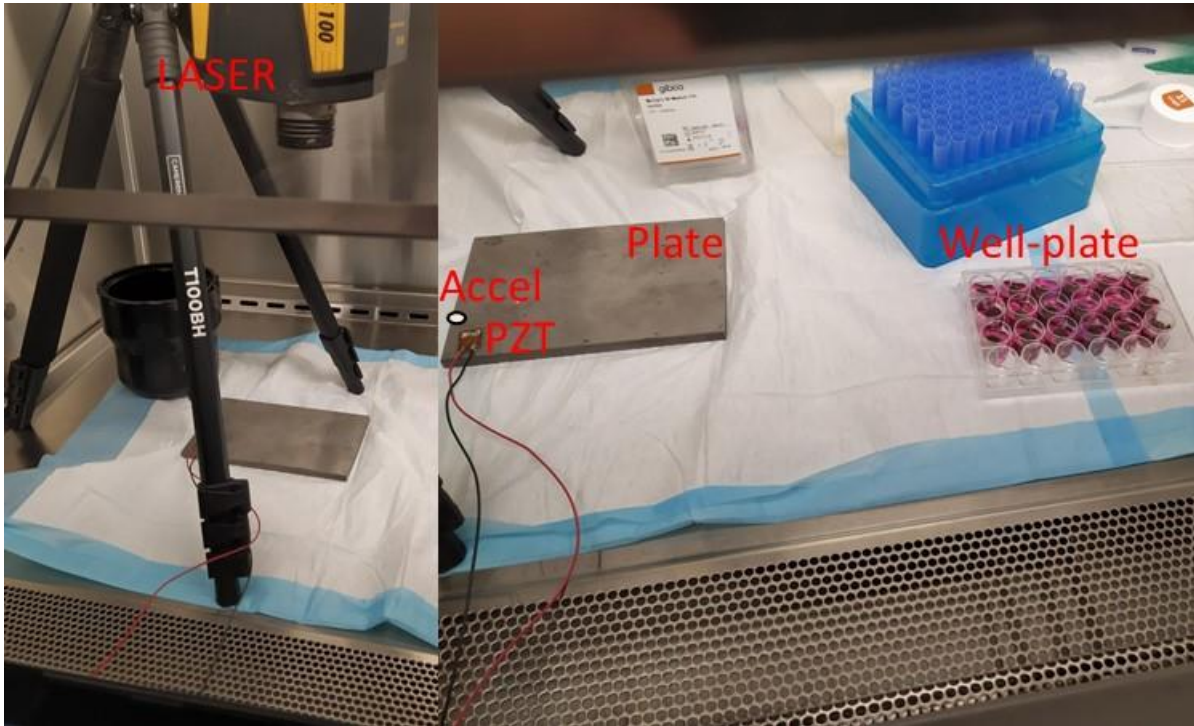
Sensors& actuators used: Laser Doppler Vibrometer and Accelerometer for measuring velocity. PZT exciting the plate.
